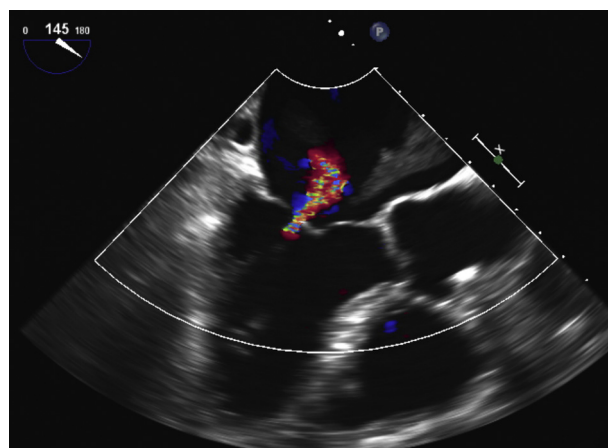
Transesophageal long-axis view with color Doppler demonstrating mild mitral regurgitation ([Supplemental Video 4](#)).
